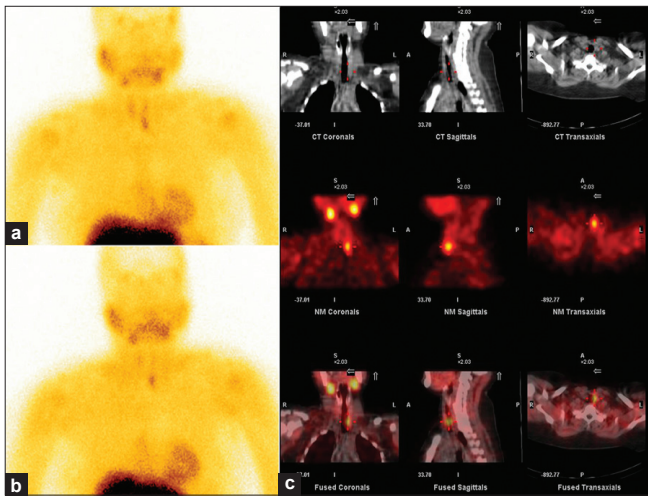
A 50-year-old female presented with renal stone disease with hypercalcemia. Dual-phase Tc99m sestamibi scan (a) early images show focal area of tracer concentration below left lobe of the thyroid; (b) delayed images show retention of tracer uptake in the anterior neck left of the midline. (c) SPECT/CT localizes increased tracer uptake to the left paratracheal region
